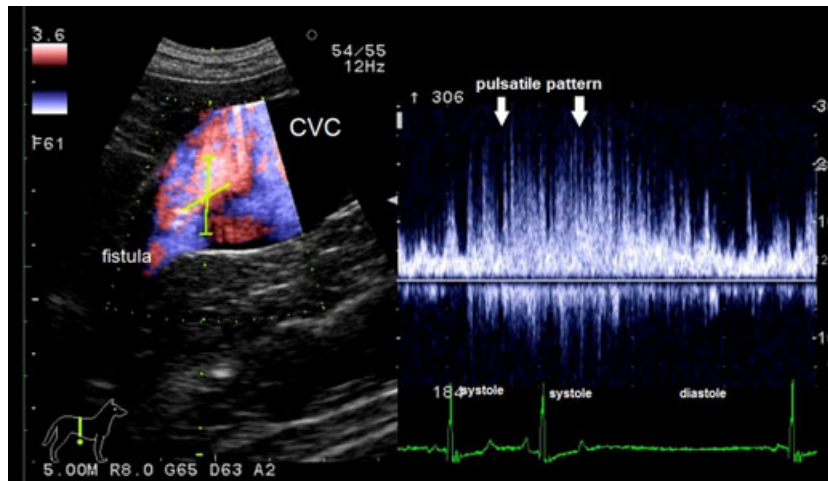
Doppler ultrasound image of the caudal vena cava (CVC) obtained from caudal abdomen. Continuous Doppler image showing an arterIALIZED flow or pulsatile pattern (arrows) across the fistula entering the CVC.
